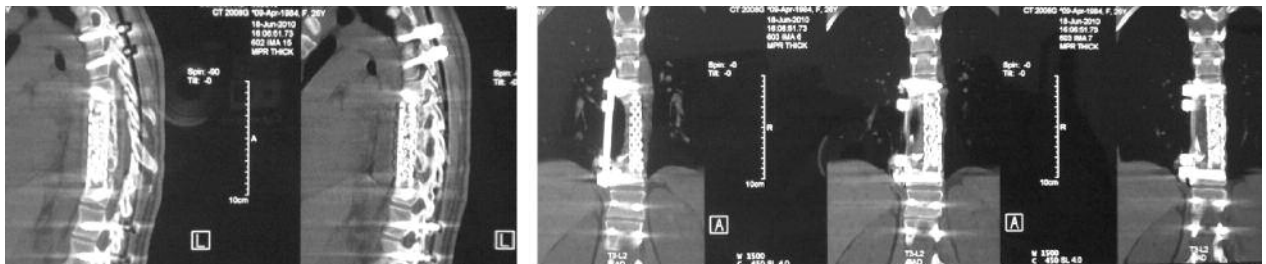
Post-operative 2 years. (a) Sagittal and (b) Coronal CT views. Three level corpectomy, cage implantation and anterior instrumentation performed.
